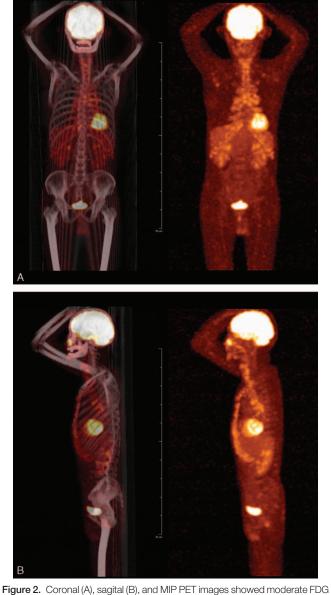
Coronal (A), sagital (B), and MIP PET images showed moderate FDG accumulation in the nasal cartilages, laryngeal cartilages, all costal cartilages, tracheobronchial tree and the axillary, hilum and mediastinal lymph nodes. FDG=fluorodeoxyglucose, MIP PET=maximum intensity projection positron emission tomography.
